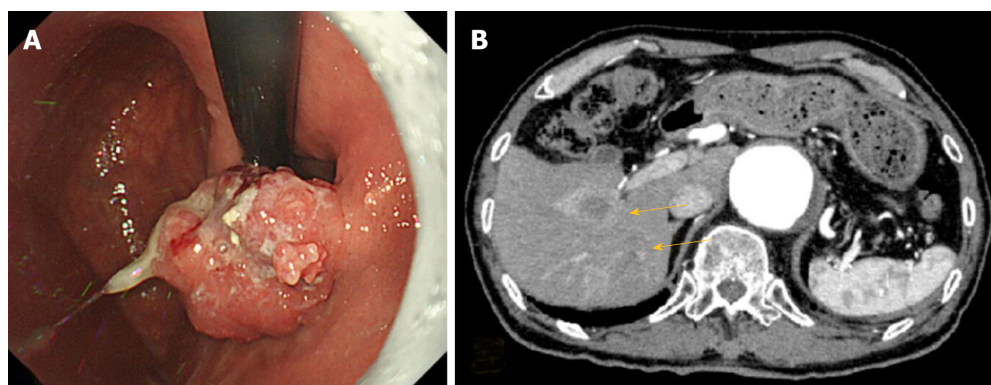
Objective image findings at the first visit to our institute. A: EGD findings before treatment. EGD found a protruding lesion, 20 mm in diameter, at the gastric cardia; B: Abdominal CT with contrast before treatment; CT showed multiple mass lesions throughout the liver (arrows). EGD: Esophagogastroduodenoscopy; CT: Computed tomography.
